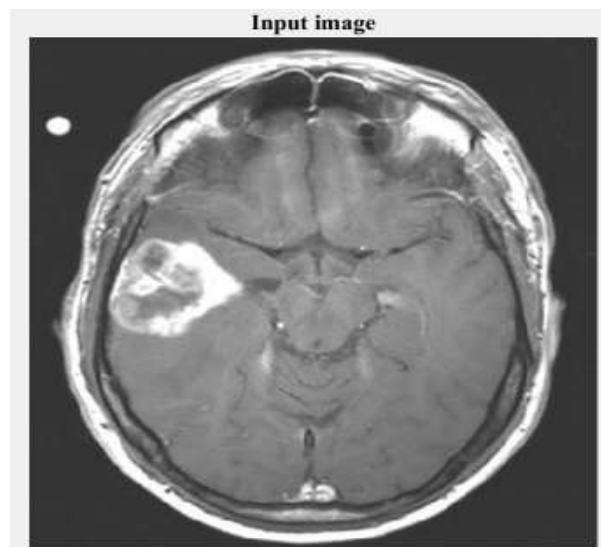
Imported Input MRI image from Dataset
